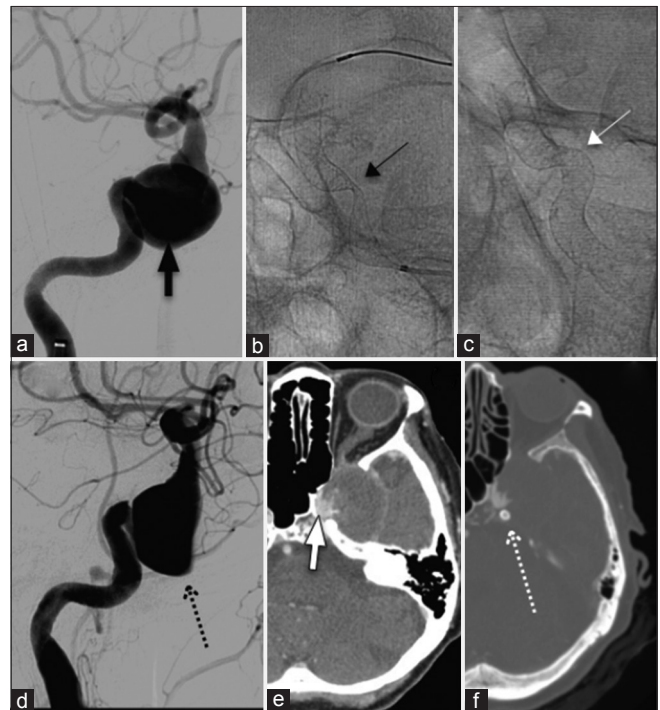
A 78-year-old female with diplopia. (a) Angiogram showing a large aneurysm in the left cavernous region (thick black arrow). (b) We decided to use a FD; however, there the FD kinked after deployment (thin black arrow). (c) Better opening of the FD was seen after angioplasty (white thin arrow). (d) Controlled angiogram after treatment showing contrast stagnation in the aneurysmal sac (black dot arrow). (e and f) CT angiogram 6 months postoperatively showing a residual sac (thick white arrow) and good patency of the FD (white dotted arrow). FD – Flow diverter; CT – Computed tomography
